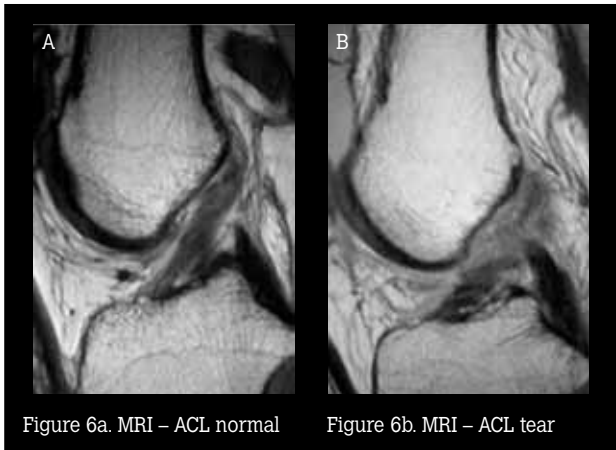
MRI – ACL normal
